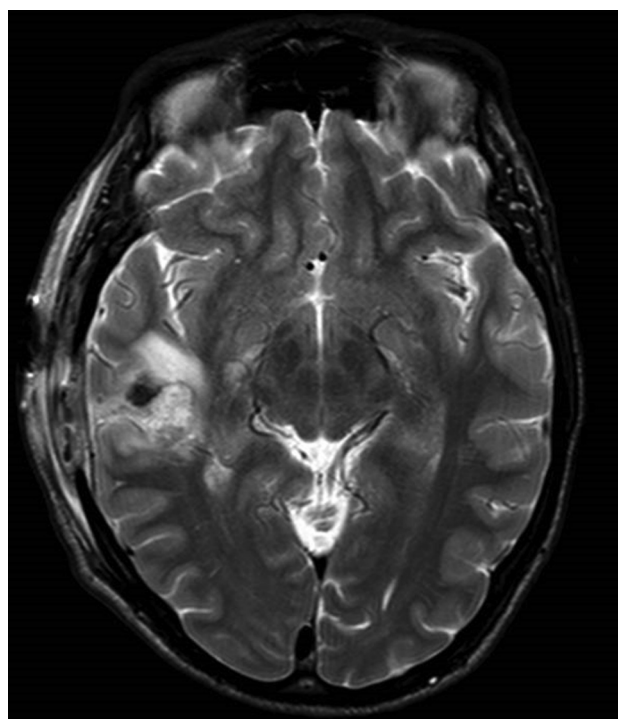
Case 3. Postoperative T2-weighted magnetic resonance imaging sequence (axial view) showing the area of hemangioma resection and blood clot in the surgical cavity.
